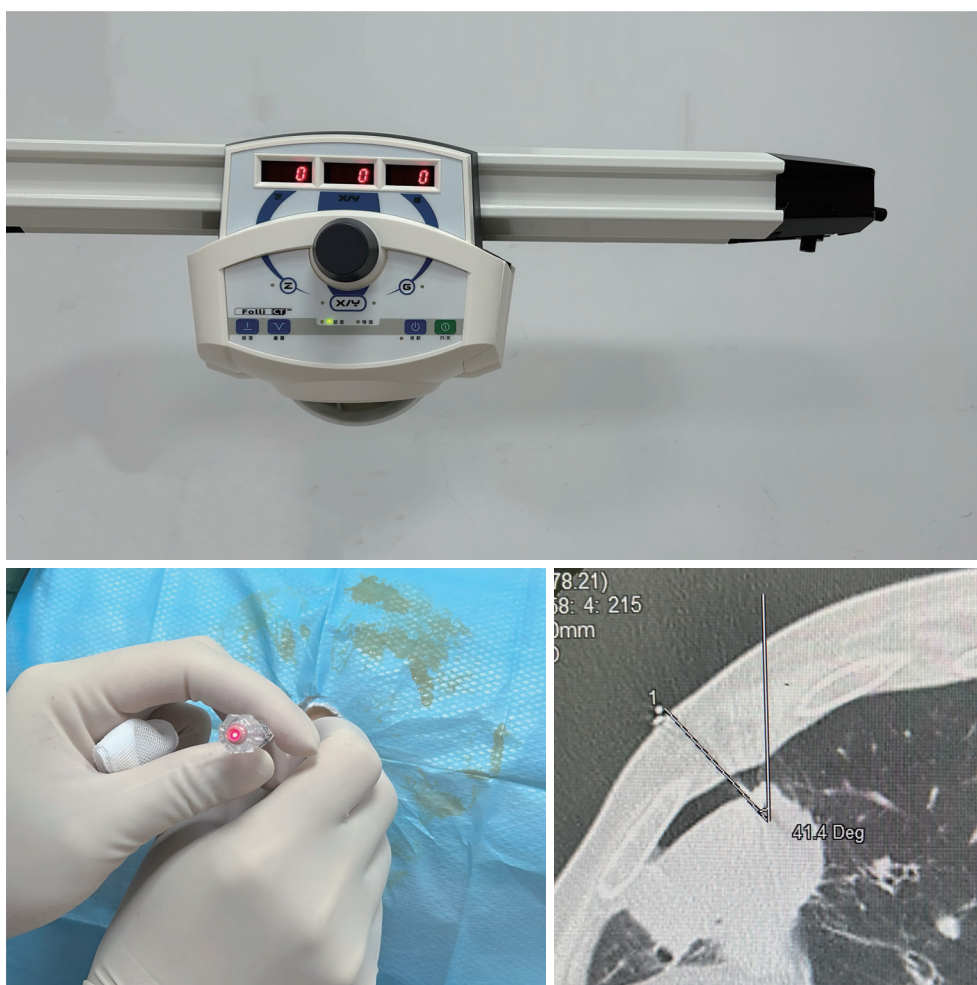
The laser-guidance machine. During the puncture process, maintain a laser spot on the tail of the puncture needle to ensure that the puncture path aligns with the planned path. During the CT scan, the puncture angle, which corresponds to the angle of the laser, is measured on the CT images based on the planned puncture path. CT, computed tomography.
